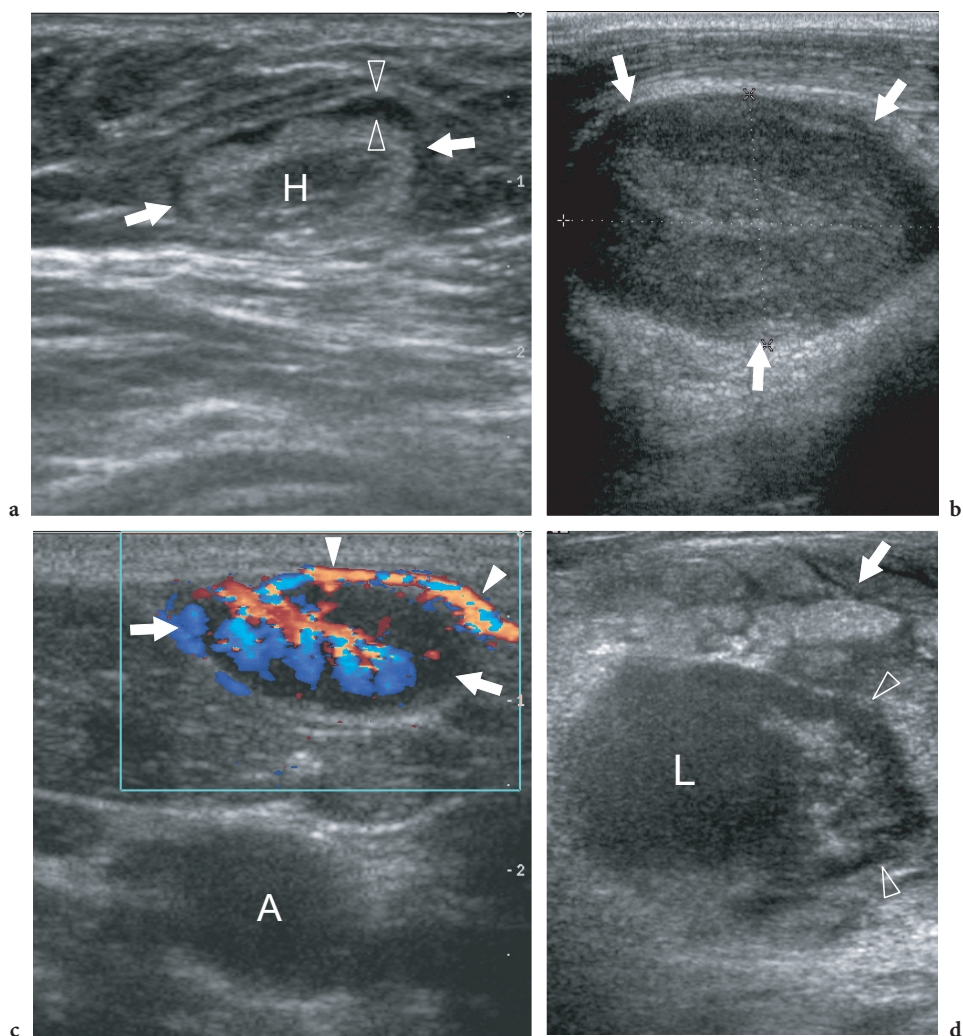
Groin lymphadenopathies. Spectrum of US findings in four different cases. a Long-axis 12–5 MHz US image of a normal lymph node (*arrows*) with atrophic hypoechoic cortex (*arrowheads*) and a thickened hilum (*H*) due to abundant fat deposition. b Long-axis 12–5 MHz US image of a metastatic node from adenocarcinoma. Observe the considerable enlargement and rounding of the lymph node (*arrows*). The central hilar area is no longer demonstrated. c Long-axis 12–5 MHz color Doppler US image of a reactive lymph node (*arrows*) shows a single vascular pole (*arrowheads*) branching with a root-like pattern within the hilum. *A*, common femoral artery. d Nodal abscess. Transverse 12–5 MHz US image of the inguinal region in a patient with groin infection reveals a hypoechoic fluid collection (*arrowheads*) in the subcutaneous tissue spreading from a node (*L*) and infiltrating among the adjacent fat lobules (*arrow*)
